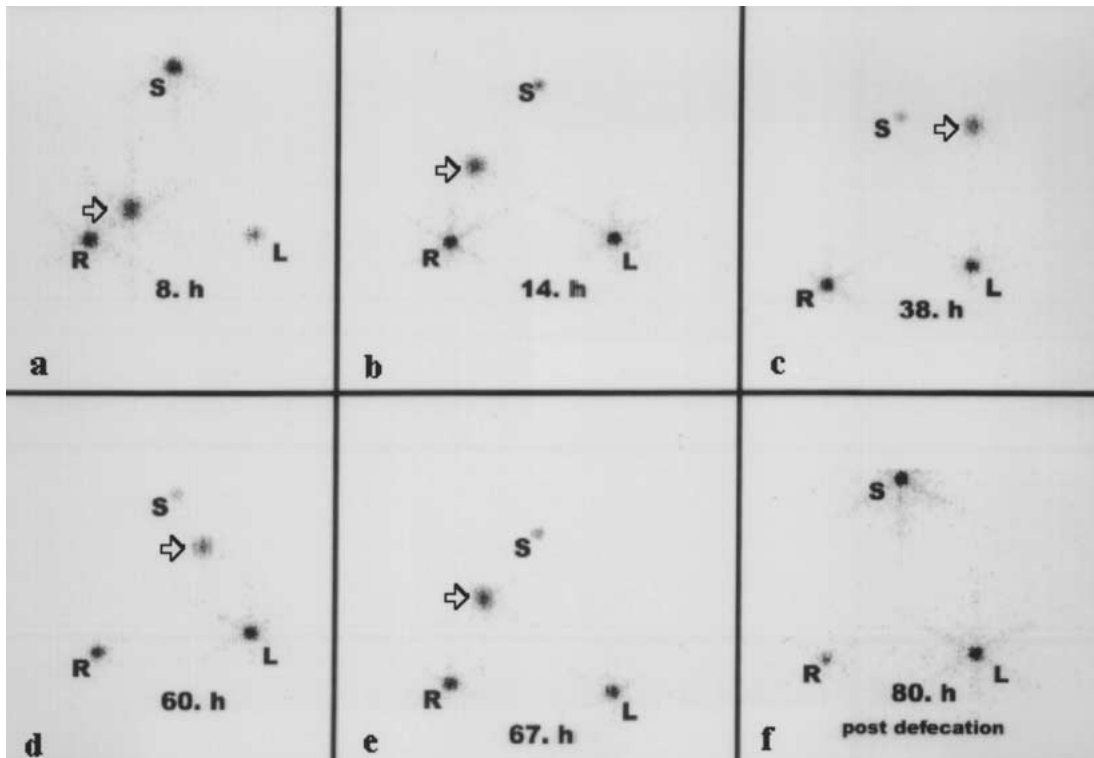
Anterior abdominal scintigraphic images of iodine 131-filled minicontainers (arrows) and capsules at 8, 14, 38, 60, 67, and 80 h in a constipated patient. *L* left anterior iliac crest; *R* right anterior iliac crest; *S* xiphoid process.
